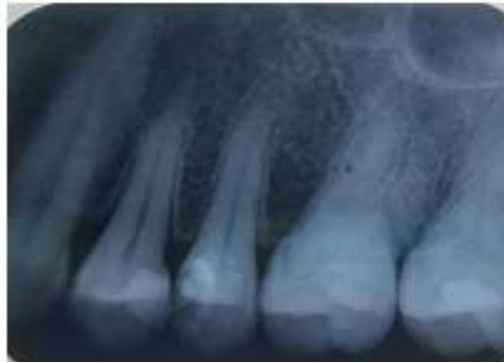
Initial dental radiographic photos of 24 (diagnosis)
